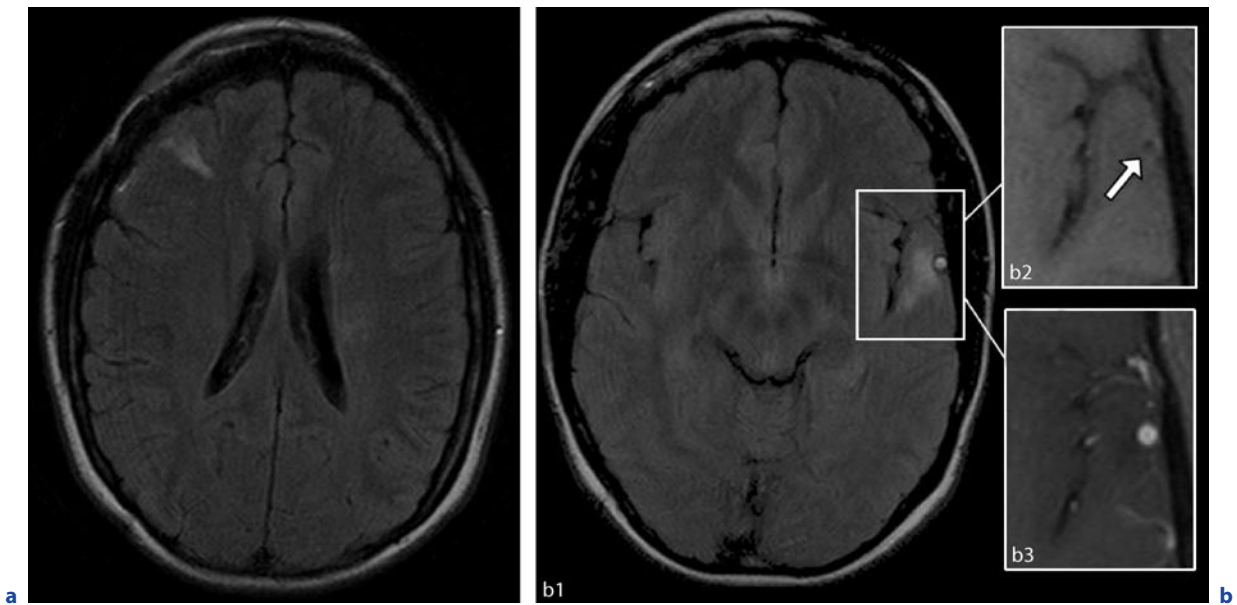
Cerebral arteriopathy in scleroderma. A 32-year-old woman with linear scleroderma “en coup de sabre.” Focal epilepsy starting five years ago was the first sign of cerebral affection. a Axial FLAIR-weighted image. b Axial FLAIR-weighted images (*b1*). Detail images of axial T1-weighted images of the left anterior temporal pole before (*b2*) and after contrast administration (*b3*). Right frontal (a) and left temporopolar (*b1*) cortical and subcortical white matter
